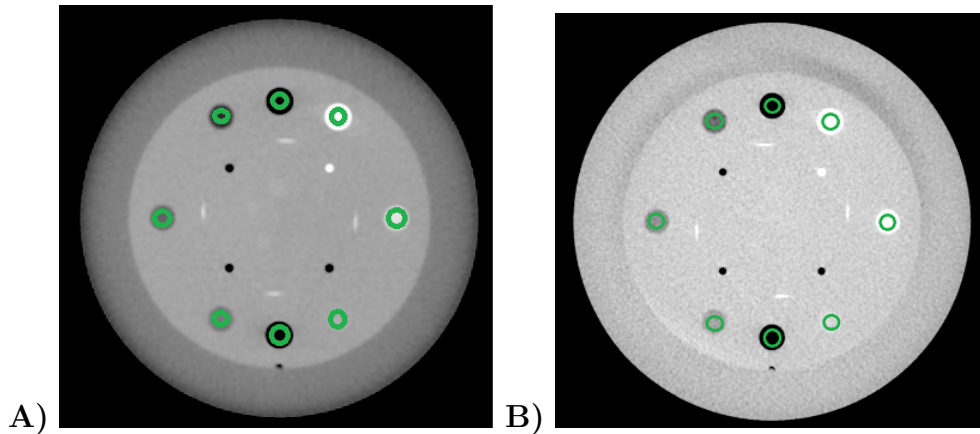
A) Axial slice of Catphan acquired with the full-fan and B) half-fan mode CBCT with area of interest for each of the seven material inserts
